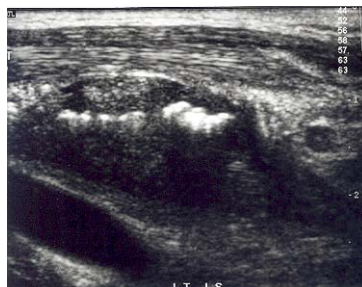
Sagittal ultrasound image of the left perithyroid region shows hyperechoic gas pockets within the pyriform sinus fistula.
